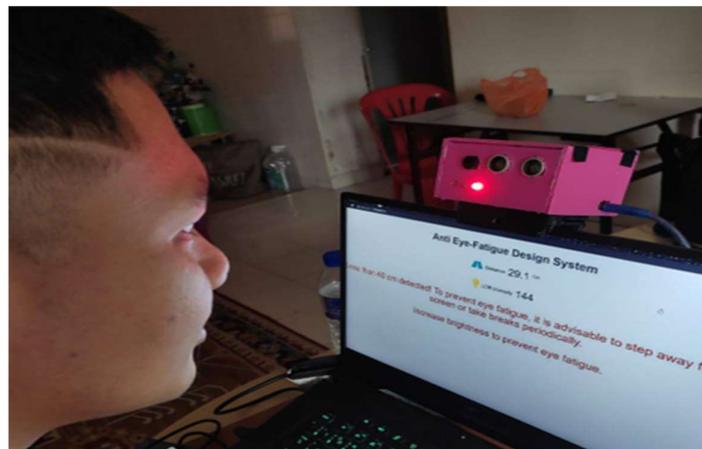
Red led on when the ultrasonic sensor is less than 40 cm
